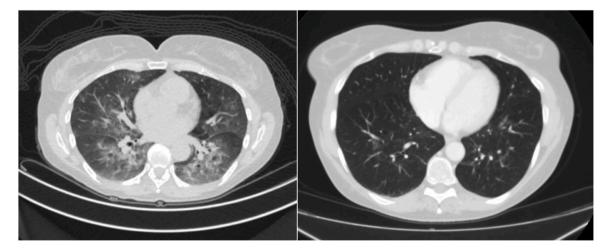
CT images of a patient at diagnosis of the pneumonitis (left image) and after 4 weeks of treatment with high dose prednisolone (right image).
